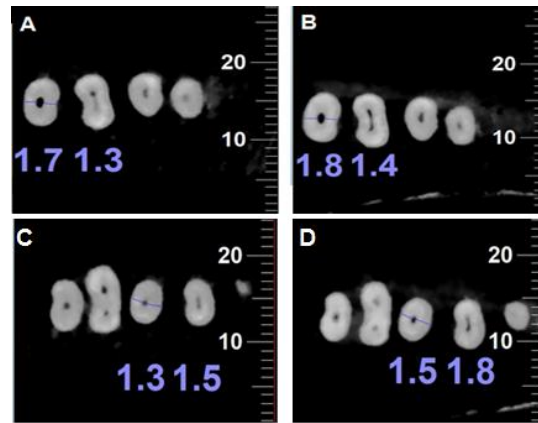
CBCT images of the teeth; A: Traditional Endodontic Access Cavity (TEC) design; B: Contracted Endodontic Access Cavity (CEC) design.
